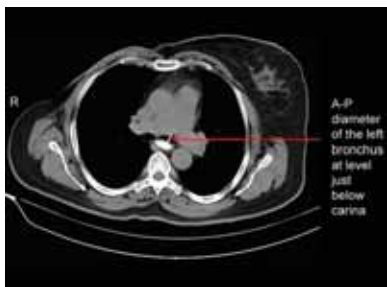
Computed tomography-guided measurement of left bronchus
